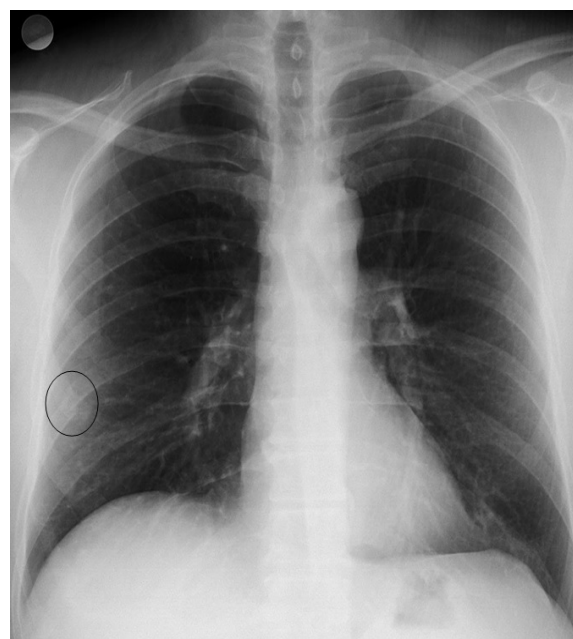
A fracture on the anterior of the eighth rib was identified in the posterior-anterior lung radiograph.
